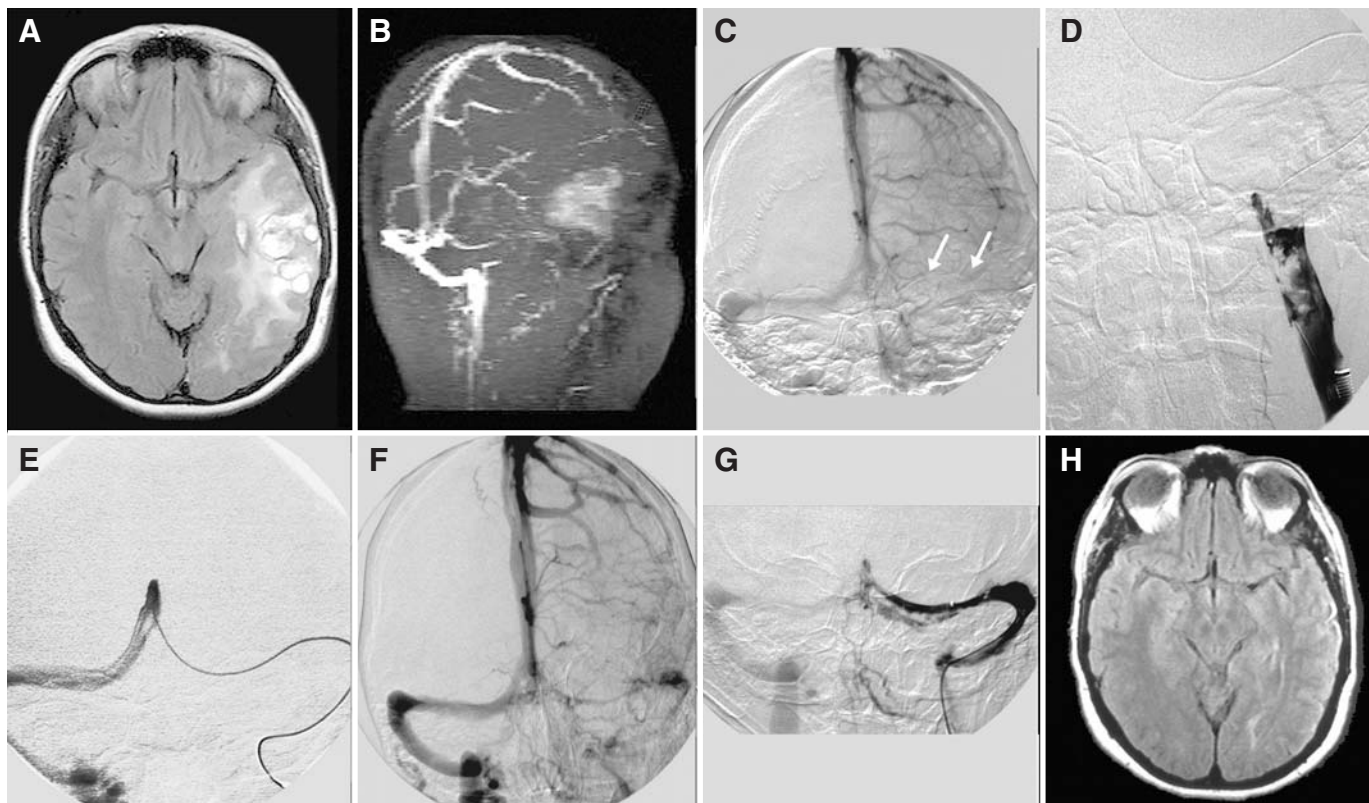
A, axial fluid attenuation inversion recovery MRI scan demonstrating hemorrhage and edema distributed throughout the left temporal lobe. B, reconstructed maximal intensity projection of the two-dimensional MRV source data depicting complete occlusion of the left transverse sigmoid system. Hyperintensity within the region of the left temporal lobe represents "shine-through" from the large T1-weighted hyperintense hematoma. C, venous phase of an angiogram performed from a catheter positioned within the left internal carotid artery demonstrating complete occlusion of the left transverse-sigmoid system (arrows). Prolonged and intense cortical venous opacification is evident over the left cerebral hemisphere. D, venogram performed through an 8-French guiding sheath positioned within the left internal jugular vein demonstrating a large, irregular thrombus extending into the jugular bulb and distal jugular vein. E, venogram performed through a
